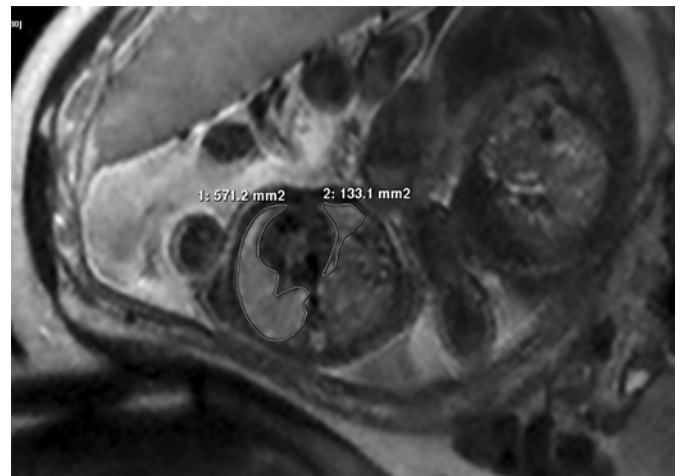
Fetal MR image, axial SSFSE T2-weighted image. Twins at 29 weeks' gestation. Twin A with a left congenital diaphragmatic hernia. TFLVs were calculated for each twin from consecutive sections in 2 out of 3 imaging planes. Lung area measured by manually outlining the lung boundary, excluding pulmonary hila.
